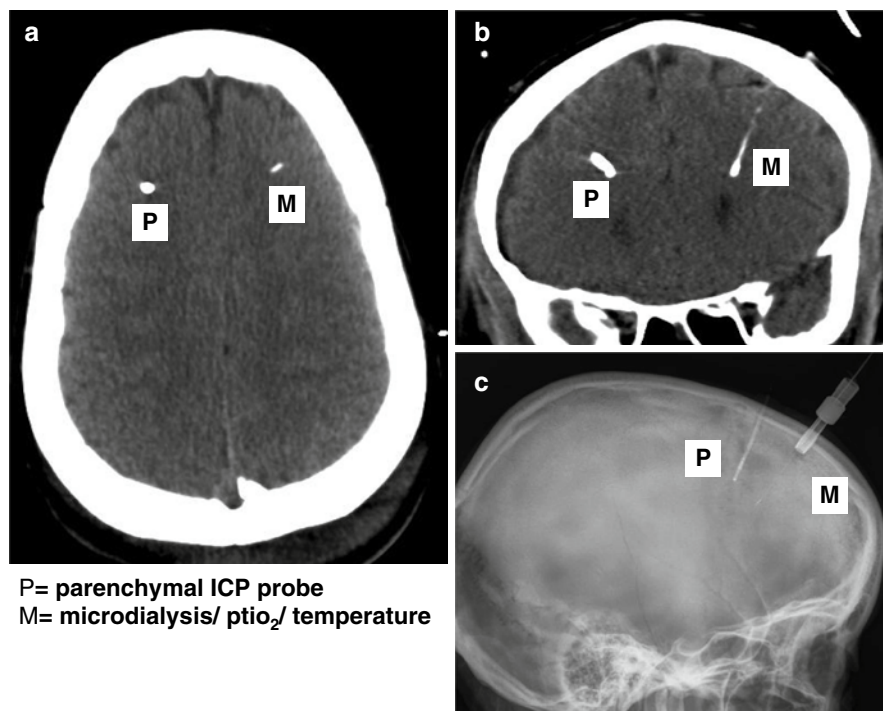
Examples of insertion of parenchymal intracranial pressure (ICP) probe (*P*) and microdialysis combined with partial pressure tissue oxygenation (ptiO₂) and temperature probe (*M*) (using the same burrhole). Figure 2.13a and b depict projection of probes in axial (a) and coronal (b) computed tomography (CT) scans. Projection of the inserted probes is also seen in the lateral aspect of a conventional X-ray of the head (c)
